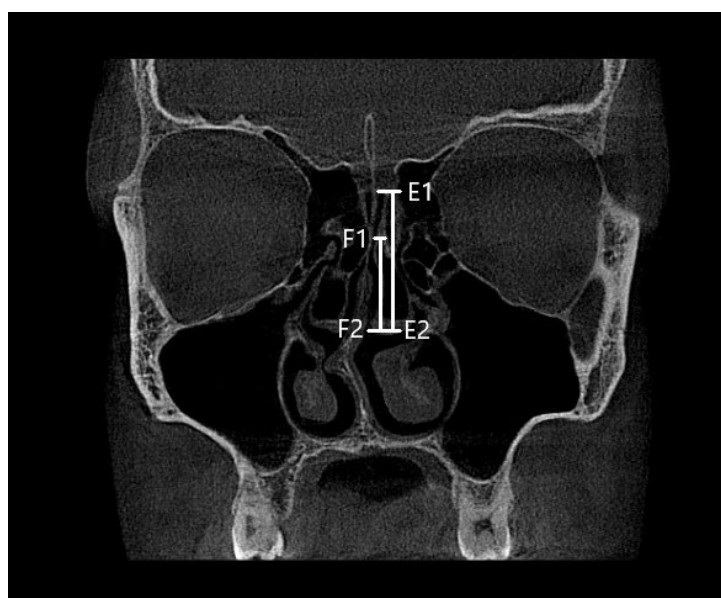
Coronal CBCT section showing identification of CB based on the criteria proposed by Stallman et al.¹⁹ The E1–E2 line represents the vertical height of the middle turbinate, while the F1–F2 line indicates the extent of pneumatization due to CB
